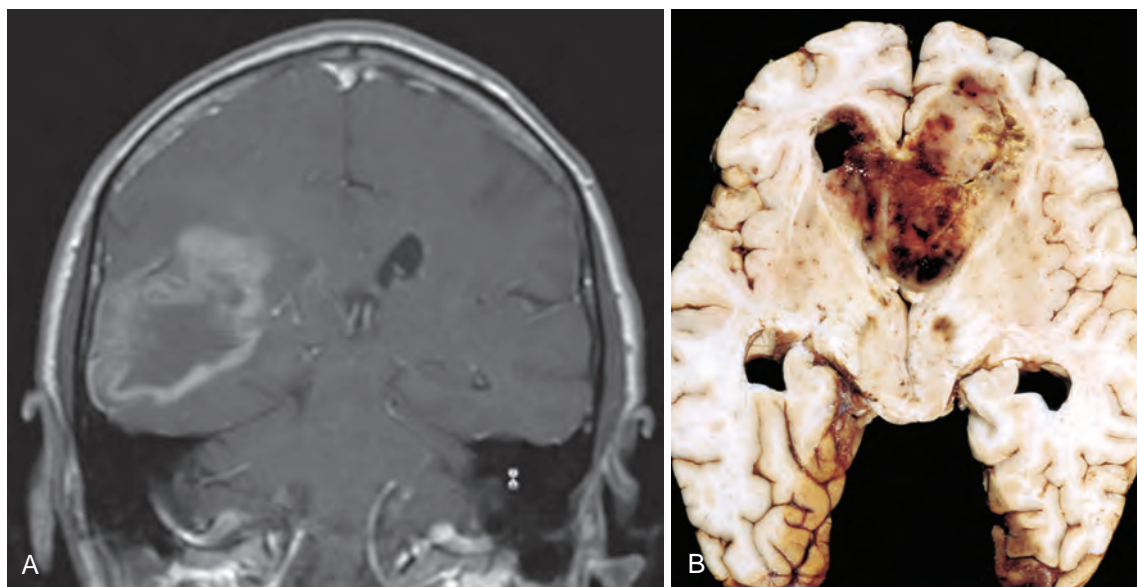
(A) Contrast T1-weighted coronal magnetic resonance image shows a large mass in the right temporal lobe with “ring” enhancement. (B) Glioblastoma appearing as a necrotic, hemorrhagic, infiltrating mass.
